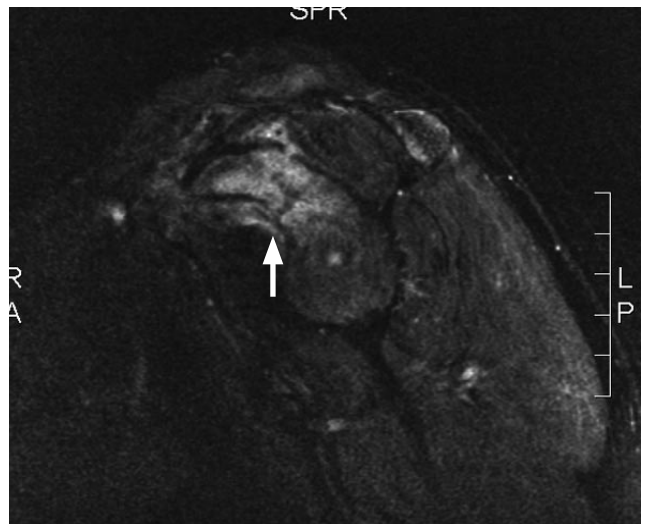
T<sub>2</sub>-weighted magnetic resonance imaging shows fractured epiphysis of coracoid with surrounding edema (arrow).
